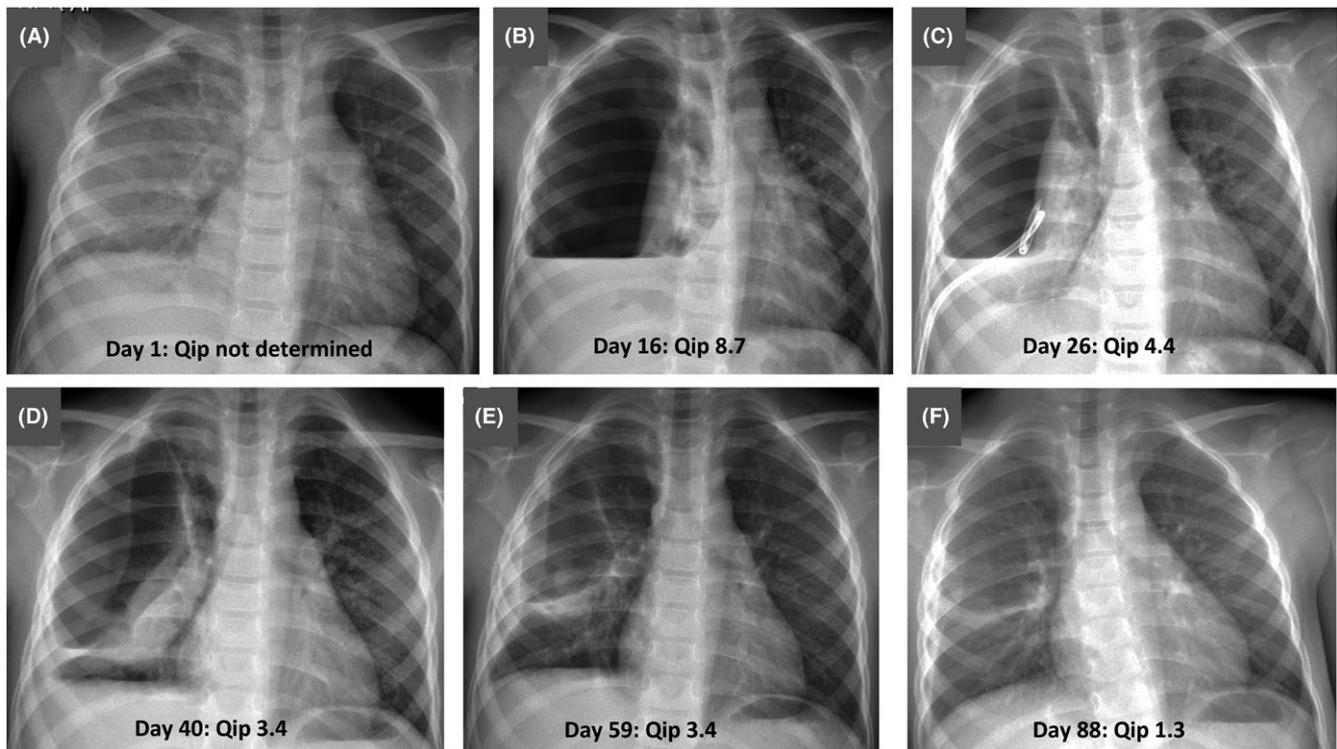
Clinical and radiological progression of patient 4, showing correspondence with the Qip in days post-admission. Patient 4 was admitted for pneumonia of the right lung with a small effusion (A). In spite of good clinical progression and fever remission on treatment with cefotaxime, a growing effusion and hydropneumothorax developed (B) leading to a chest tube insertion, followed by slow lung reexpansion (C-E). Further improvement was observed on postdischarge control (F), with normal Qip 1.1 on day 156 (chest X-ray not shown)
